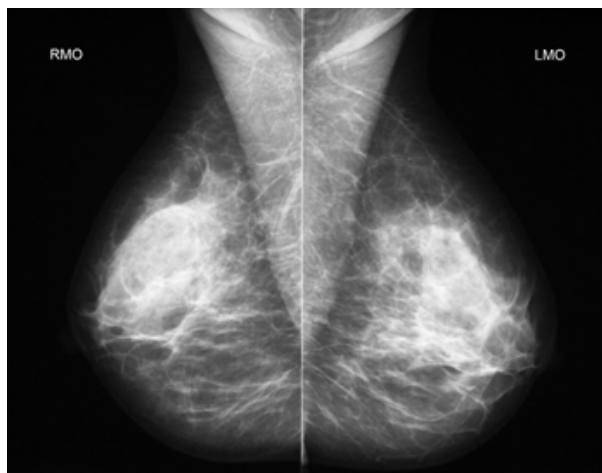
Mammogram (X-ray image of the breasts)
